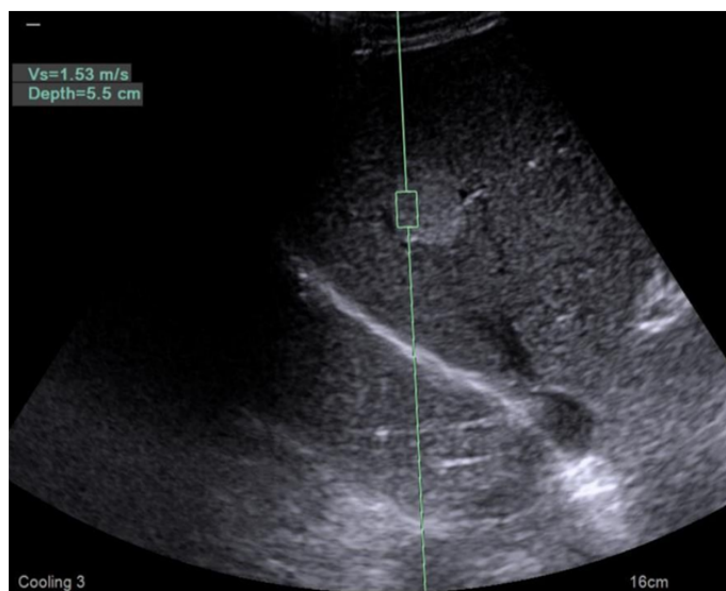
Ultrasound elastography in a haemangioma.
